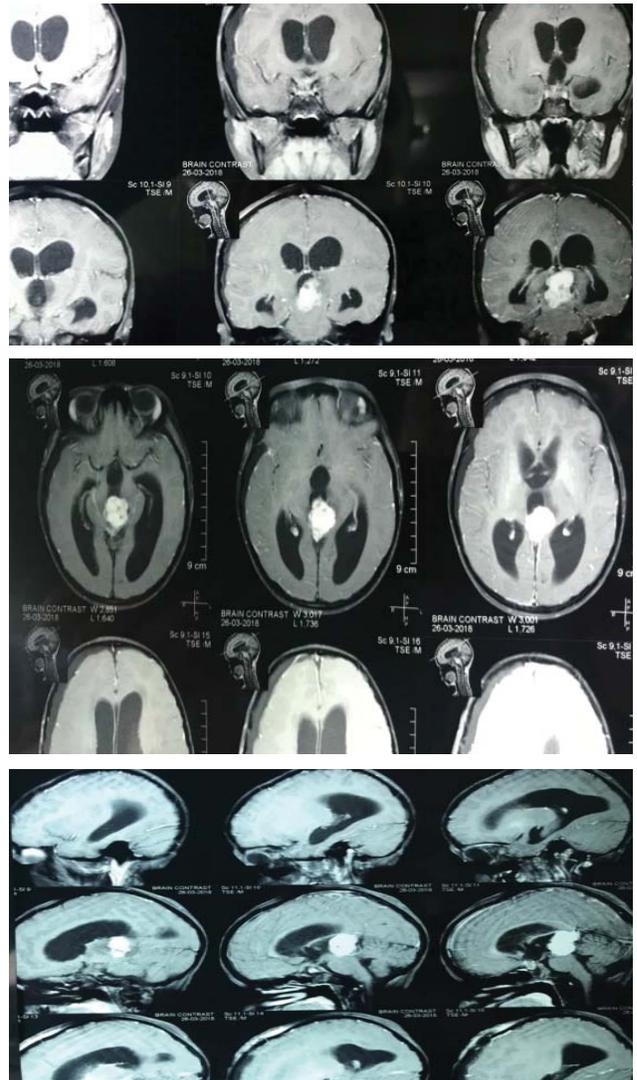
MRI Brain shows altered signal intensity in posterior part of third ventricle which is heterogeneous iso signal intensity in T1WI, high signal intensity in T2WI. On post contrast study, the lesion shows mild enhancement.
